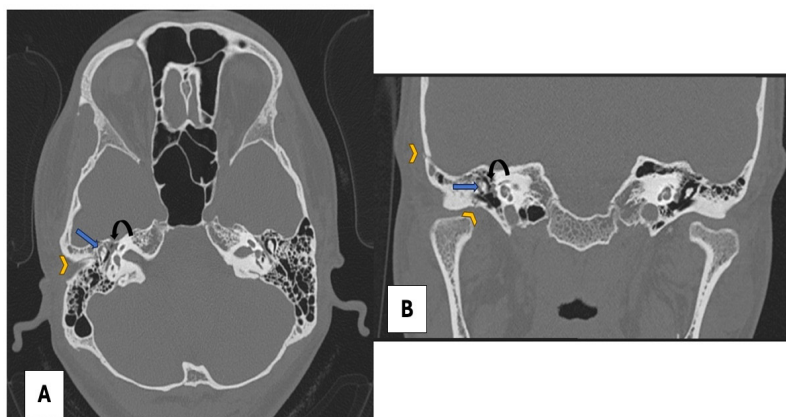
High-resolution computed tomography temporal in (A) axial and (B) coronal views showed an undisplaced longitudinal fracture of the right temporal bone extending to the petrous apex (yellow arrowhead) with diastasis of the right incudomalleolar joint (blue arrow). The first genu and the tympanic segment of the right facial canal wall appeared irregular, suspicious of fracture, with fluid within the middle ear cavity (curved black arrow)
